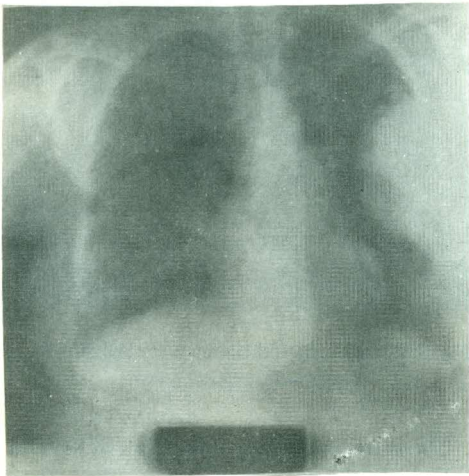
Localized mesothelioma. x-ray showing Lt. recurrence of the tumour.
